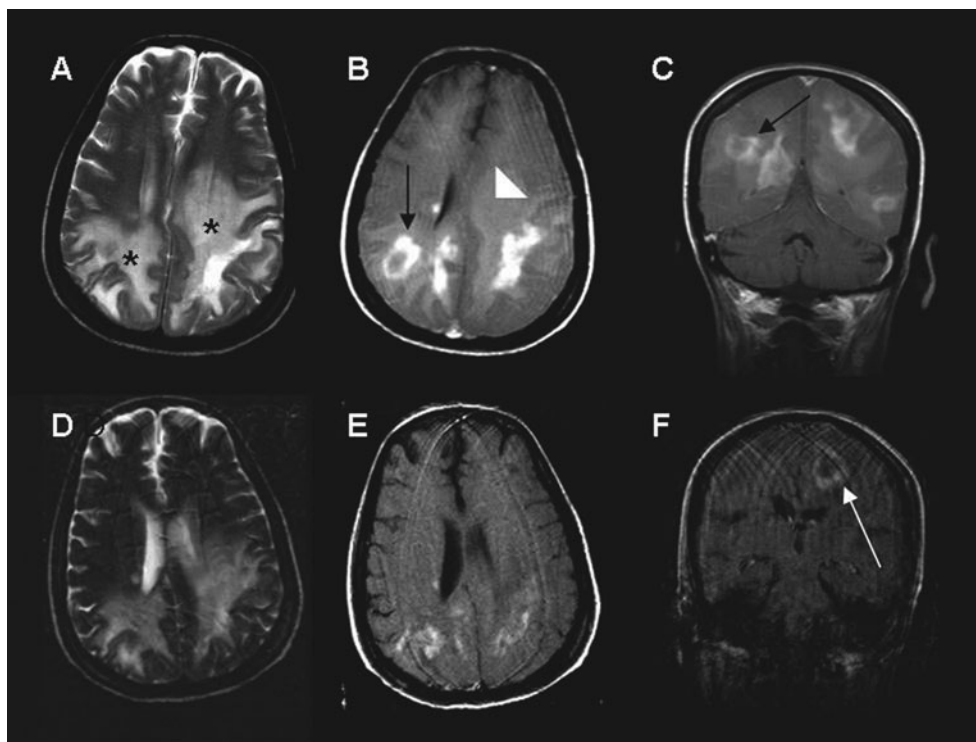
A T2-weighted image (A) shows extensive hyperintense lesions in the white matter of both cerebral hemispheres (asterisks). On contrast-enhanced T1-weighted images (B and C), irregular and ring enhancing lesions are present (black arrows). Mass effect and compression of the left lateral ventricle is evident (white arrow head, B). After treatment with steroids, mannitol and ARA-C, a partial improvement in the mass effect is observed (D and E), but ring enhancing lesions could still be seen (white arrow, F).
